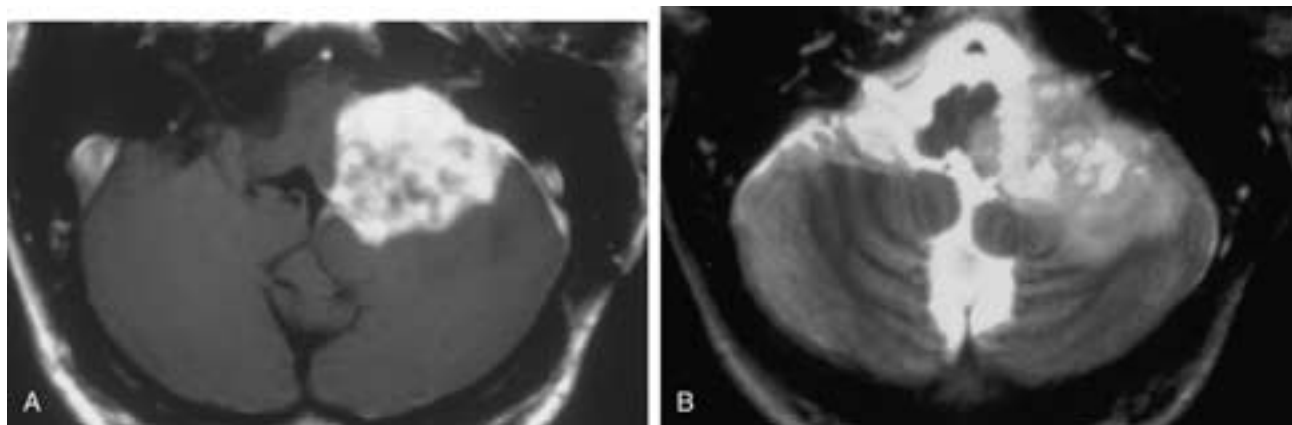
Pontine glioblastoma multiforme. A, T1-weighted postgadolinium image and B, T2-weighted image. The well-marginated intraaxial tumor involving the middle cerebellar peduncle and the cerebellar hemisphere shows heterogeneous enhancement and a mass effect on the fourth ventricle. The tumor is hyperintense on T2-weighted images. Exophytic growth of the tumor fills the cerebellopontine cistern.
